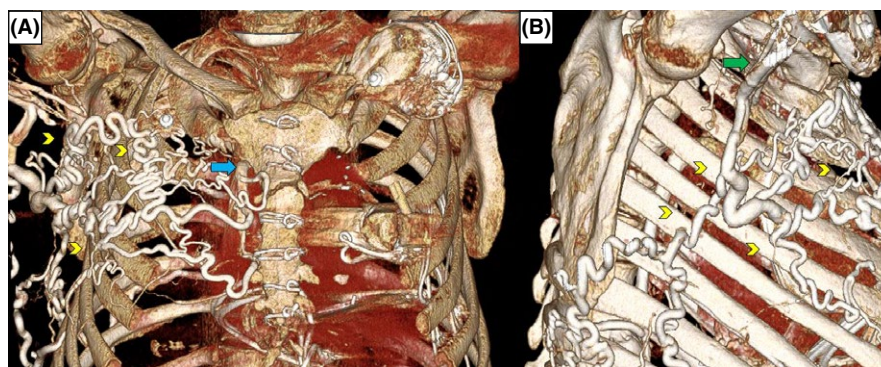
Coronal (A) and lateral (B) views of 3-dimensional reconstruction of the CT scan of the chest with contrast demonstrating intravenous contrast from the right upper extremity entering a large system of collateral vessels (chevrons) at the level of the right axillary vein (green arrow), suggesting chronic DVT/occlusion in the right axillary vein. Collaterals can be seen entering the internal thoracic vein (blue arrow)
